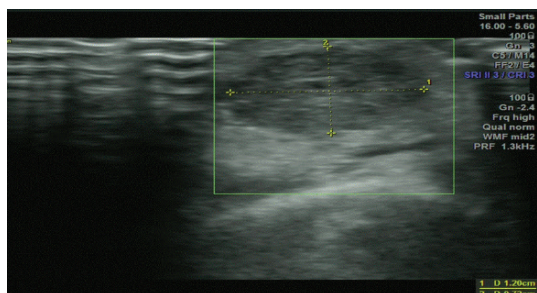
Ultrasound imaging of the tumor before resection
